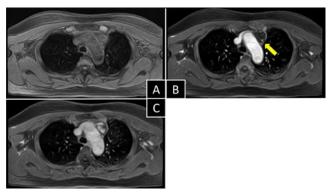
Thoracic dynamic magnetic resonance imaging (MRI)
